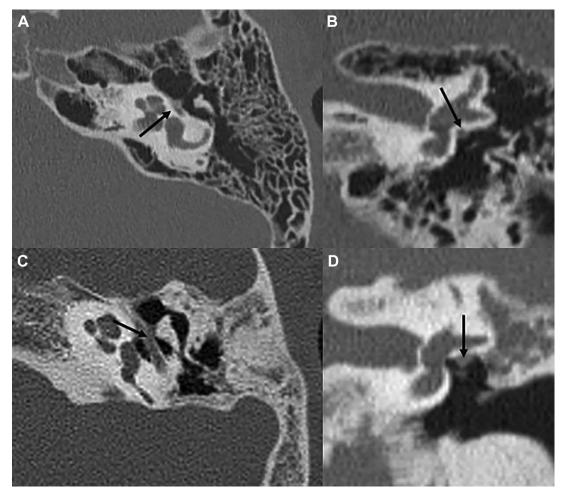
Axial (*A*) and coronal (*B*) reformatted images of temporal bone CT of a 8-year-old boy showing aberrant course of the left facial nerve (*arrow*) with inferomedial displacement of the tympanic facial canal and accompanying oval window atresia (*A* and *B*). Axial (*C*) and coronal (*D*) reformatted images of temporal bone CT scans in another adult patient showing dehiscent facial canal (*arrow*).
